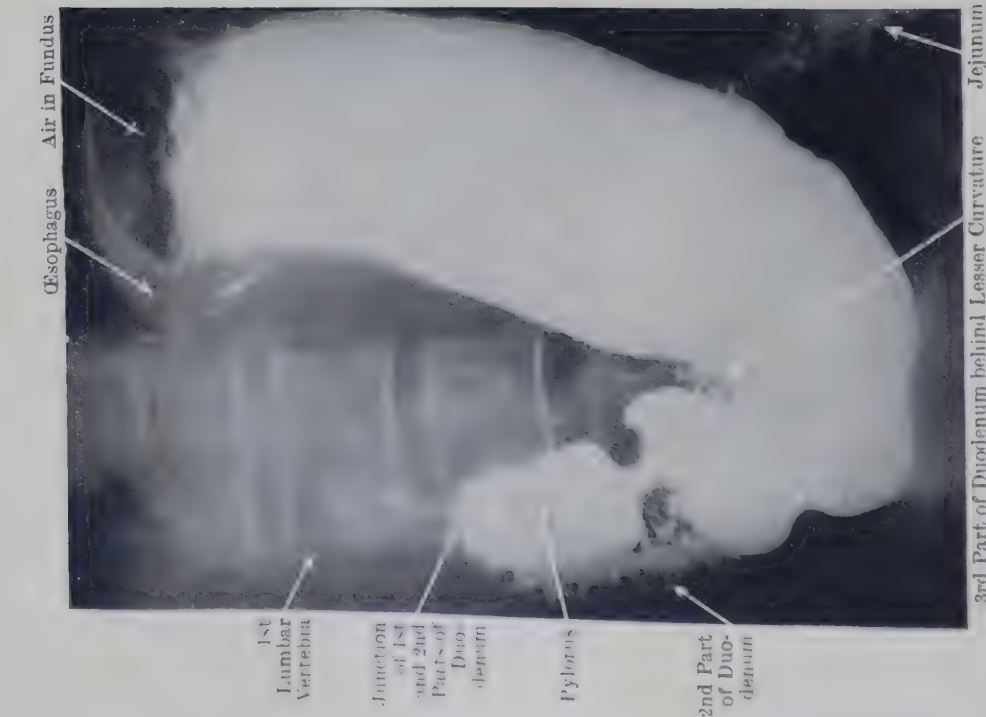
RADIOGRAPH OF J-SHAPED STOMACH (MAN, AGED 33), FILLED WITH BARIUM, SHOWING TWO PERISTALTIC WAVES (x) AND THE PASSAGE OF BARIUM THROUGH THE PYLORUS.
